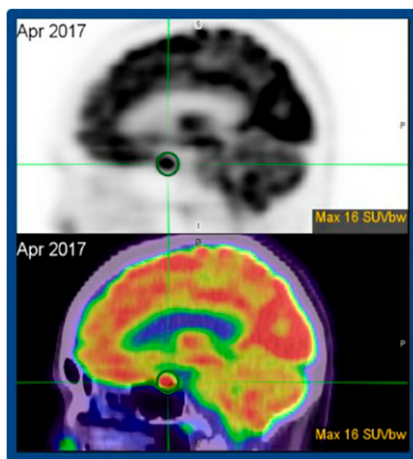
^{18}F -FDG PET in evaluation of immune-related hypophysitis and thyroiditis following combination ipilimumab and nivolumab in advanced melanoma. Example PET (top) and PET/CT (bottom) imaging shows increased uptake within the hypophysis region, which was subsequently identified in many patients to be related to abnormal hypophysal function.
